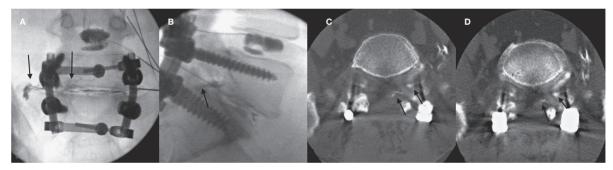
Patient is a 32-year-old man with a longstanding history of low back pain thought to be related to L5-S1 spondy-lolysis and spondylolisthesis. Approximately 1 year earlier the patient had undergone bilateral pedicle screw fixation at L5-S1. No improvement was seen in his symptoms. At diskography, the patient had 10/10 positive concordant pain at L5-S1 which was completely eliminated with lidocaine injection. A,B) AP and lateral diskogram images demonstrate residual degenerative disk changes in the L5-S1 disk with leakage of contrast into the epidural space and foramen laterally on the left (arrows). C,D) Post diskogram CT again demonstrates the active leak of diskographic contrast material into the epidural space and neural foramen on the left (arrows).
